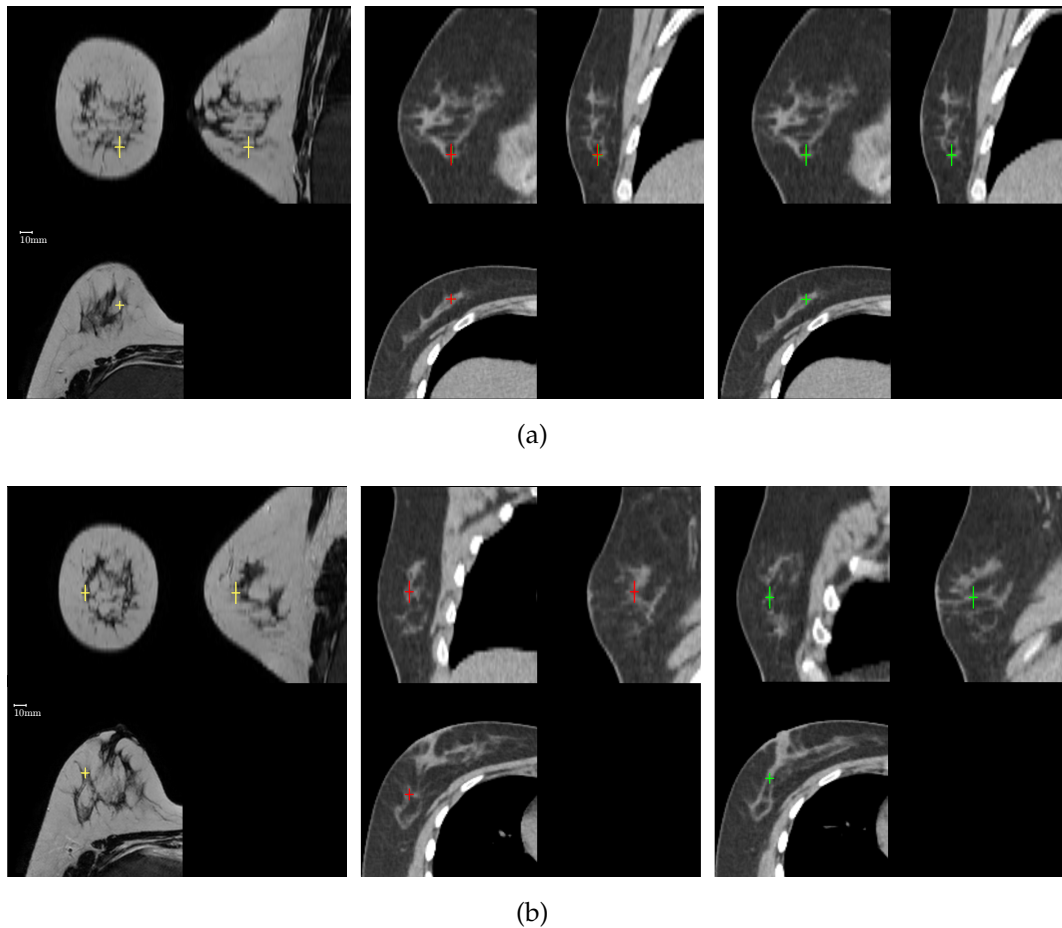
Orthogonal sections through the prone MRI and supine CT image of case P1 with corresponding landmarks selected by two observers. The first observer selected corresponding points in the prone and supine images (left and centre), whereas the control observer was asked to find the supine landmark when presented with the prone one (right). (a) shows an excellent agreement between the two observers (red and green crosses in the supine CT) resulting in a landmark distance of 1.1 mm. (b) is an example where both observers do not agree, identifying different structures with similar appearance resulting in a landmark distance of 15.2 mm.
